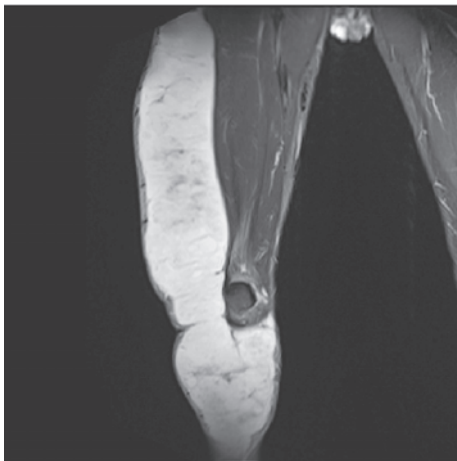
MRI of right thigh
